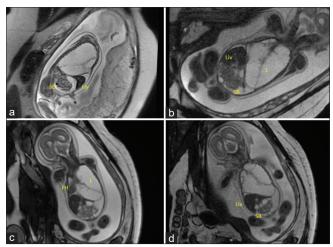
Fetal magnetic resonance imaging showing a tubular cystic lesion occupying the whole of the thorax with intact diaphragm and liver on the right side in a parasagittal section (a). Small bowel is seen distinctly occupying the center of the abdomen with the presence of ascites (a, c, d) and coronal FIESTA view (b) of the fetus showing possible discontinuation of the diaphragm with herniation of the volvulus into the thorax. SB: Small Bowel, L: Tubular cystic lesion, Liv: Liver, and FH: Fetal Heart
